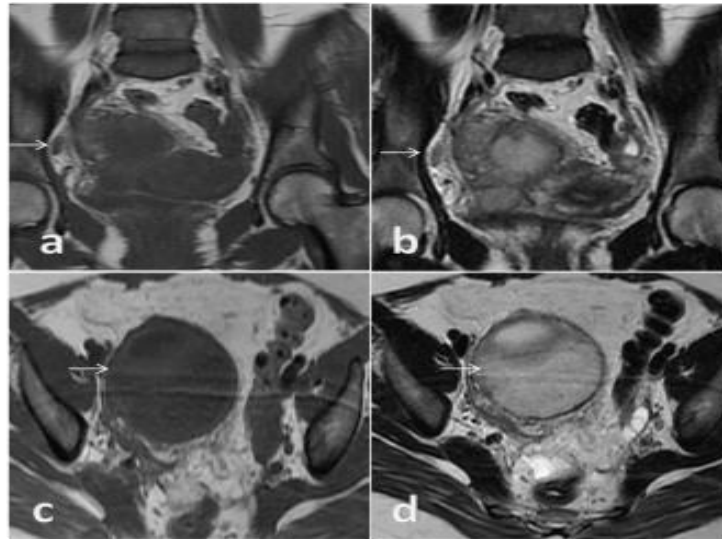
and figure 1b: Coronal sections from MRI pelvis, T1 and T2 fat sat sequences respectively, showing endometriotic deposits appearing as tiny nodular deposits over the peritoneal reflections as hypointense signals (white arrows). Figure 1c and figure 1d: Axial sections from MRI pelvis, T1 and T2 fat sat sequences respectively, showing a large, multiloculated cyst appearing hyperintense on both sequences (white arrows).
